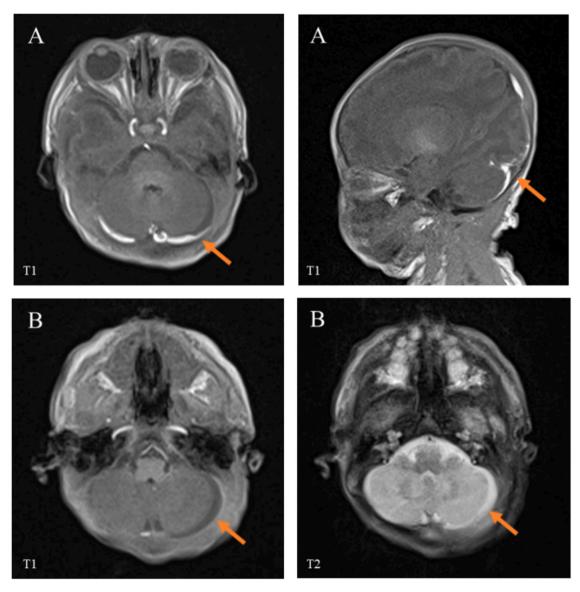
Brain magnetic resonance imaging (MRI) of the twins. Subarachnoid hemorrhage in twin A and occipital subdural effusion in twin B.
